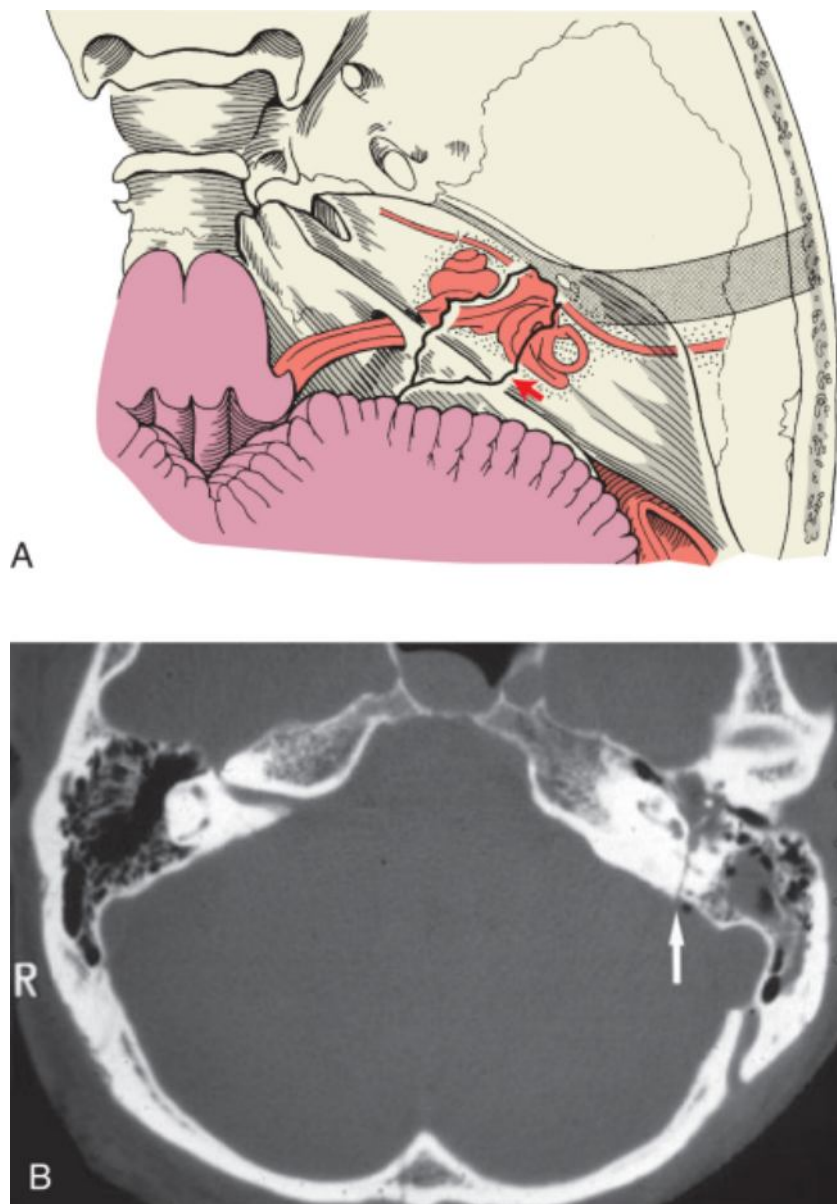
A, Transverse temporal bone fracture (*arrows*) with involvement of the otic capsule and the contents of the internal auditory canal. B, Computed tomography scan showing transverse fracture (*arrow*).
